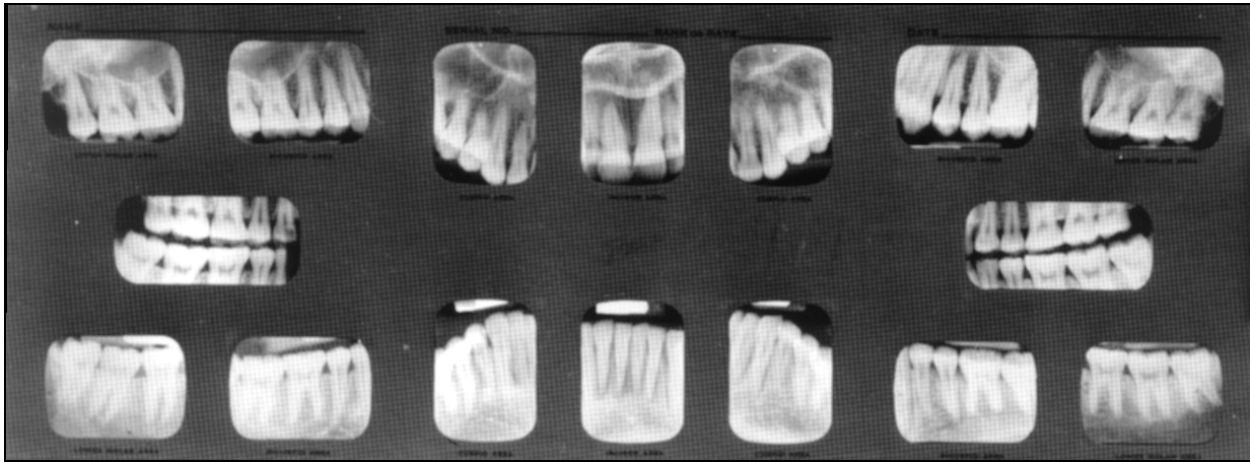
Full-mouth radiographic mount.
